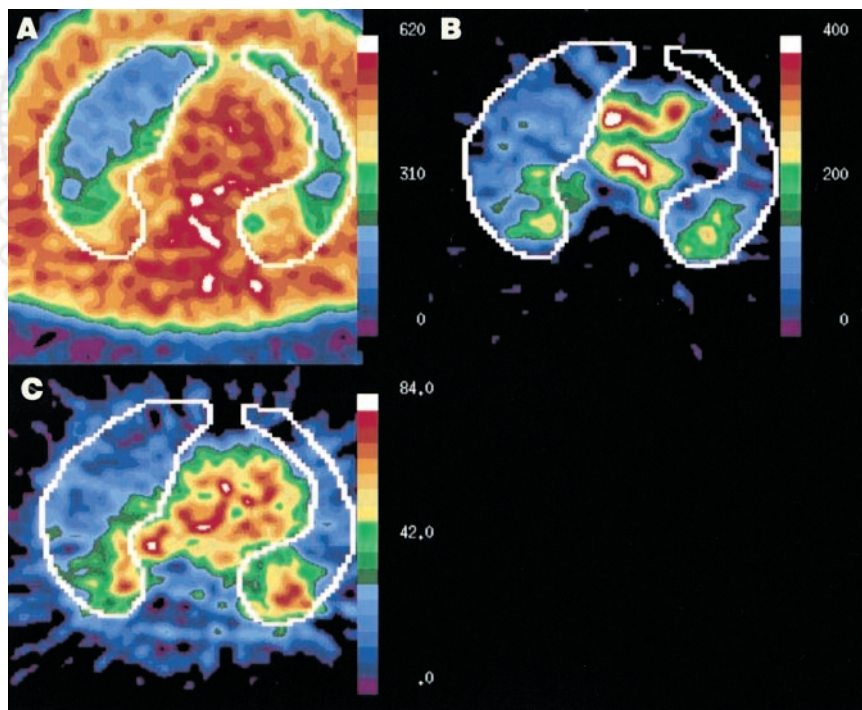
Sample PET images from patient PH226 (Table 1) with pulmonary edema. (A) Transmission image. Scale is in arbitrary units, where higher numbers indicate greater attenuation of activity (i.e., greater tissue density). Scan is comparable with typical CT scan, except with approximately 1/10th the spatial resolution. Scan is used to identify lung regions (white outlines). (B) PBF image. Units are mL/min/100 mL lung. (C) Lung water concentration (LWC) image. Units are mL H_2O /100 mL lung. Normal upper limits for LWC by these methods are approximately 25 mL H_2O /100 mL lung. Note dorsal predominance of lung water accumulation. Also note general concordance between regional blood flow and lung water distributions (i.e., there is no appreciable perfusion redistribution away from regions of increased LWC [pulmonary edema]).
